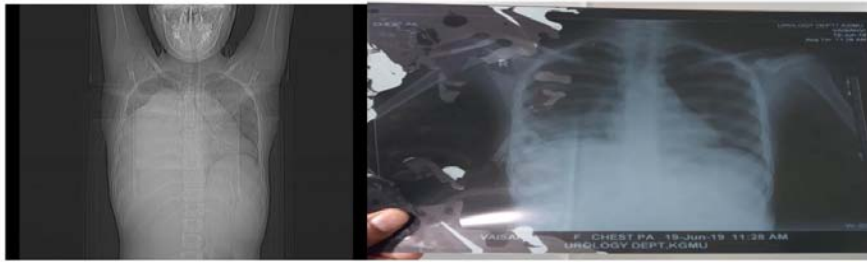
A) Chest X-ray PA view of patient showing right sided massive pleural effusion B) and after placement of thoracotomy tube.
